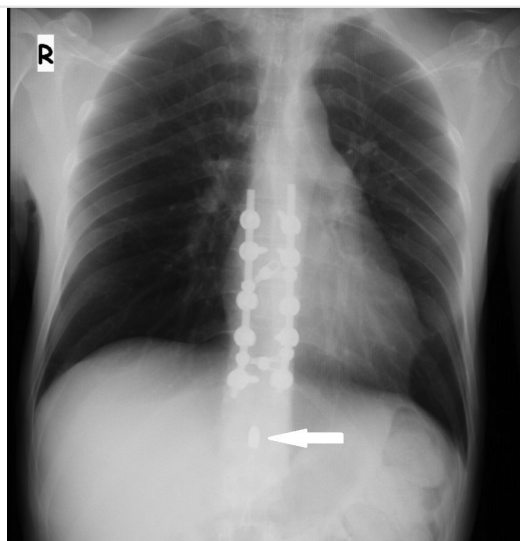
Patient's postoperative X-ray showing the bullet located at T10 level (white arrow)
